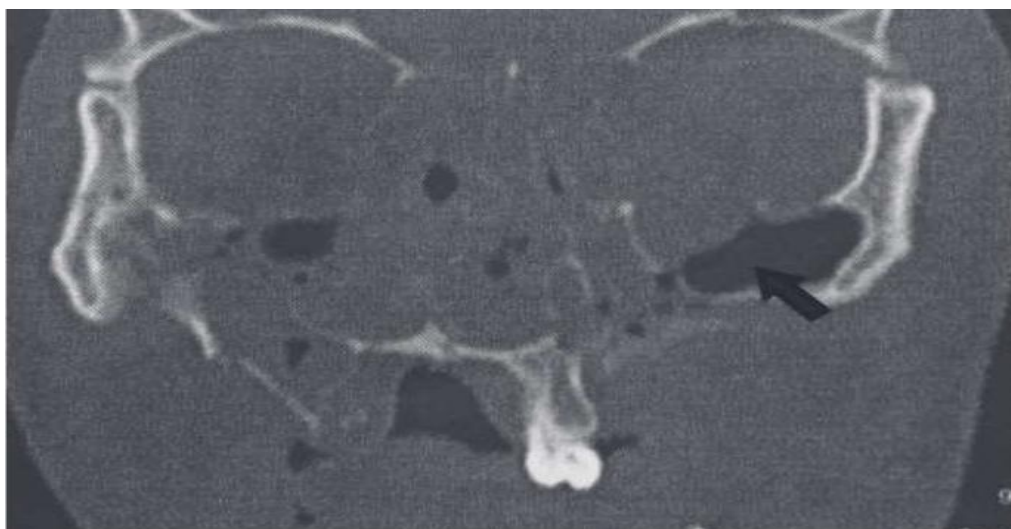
Coronal CT view indicating orbital floor (blow out) fracture [indicated by arrow].
